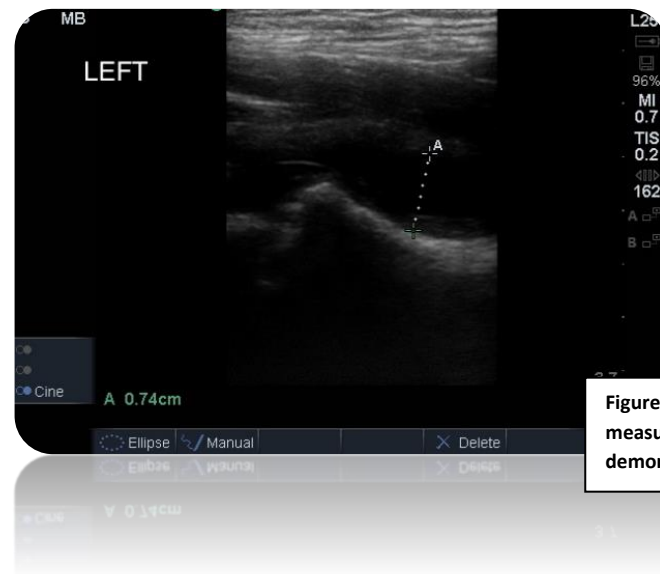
Sonographic measurement of a pediatric hip demonstrating a joint effusion.
